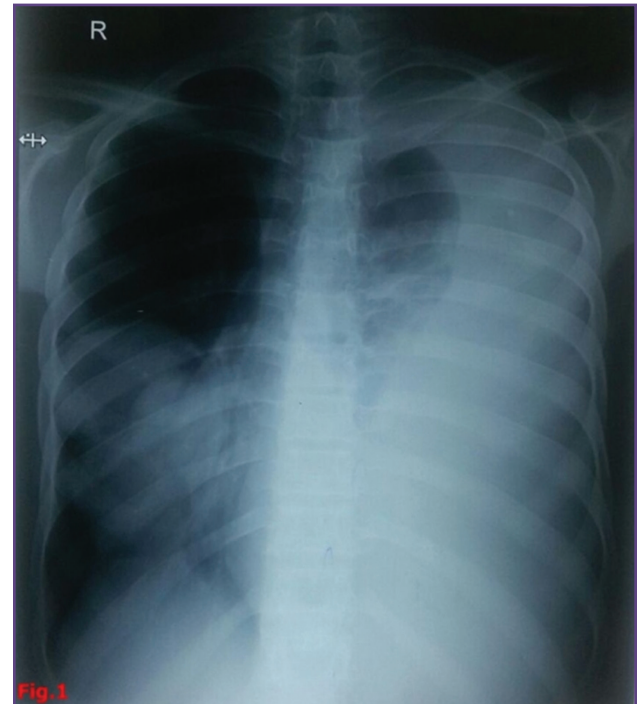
Radiograph showing massive left sided pleural effusion with right sided round well circumscribed non homogenous opacity suggestive of loculated pleural effusion.
